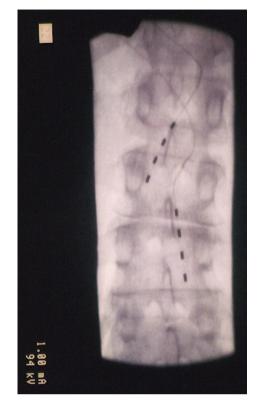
Lateral radiograph of Figure 12. Penfield 3 elevating tool assisting with placement of 3.8 mm paddles toward the S2 foramen.
